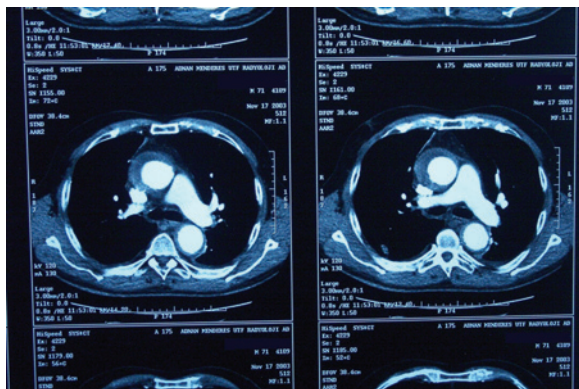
First computed tomography scan views.
